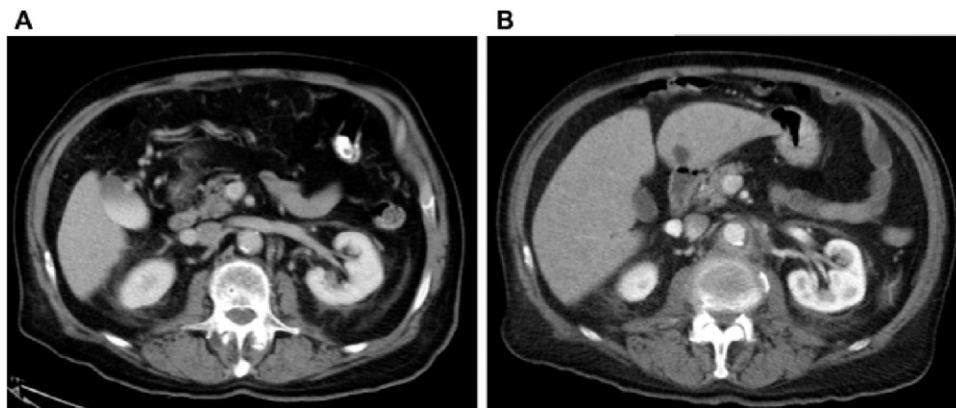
Computed tomography (CT) scan of the abdomen and pelvis obtained 2 years previously (A) for unrelated complaints showed abdominal aorta at the level of the renal veins with calcification and no surrounding inflammation. CT scan obtained during this hospital admission (B) that showed abnormal, circumferential, poorly defined soft tissue density with fluid surrounding the aorta at the level of the renal veins.
